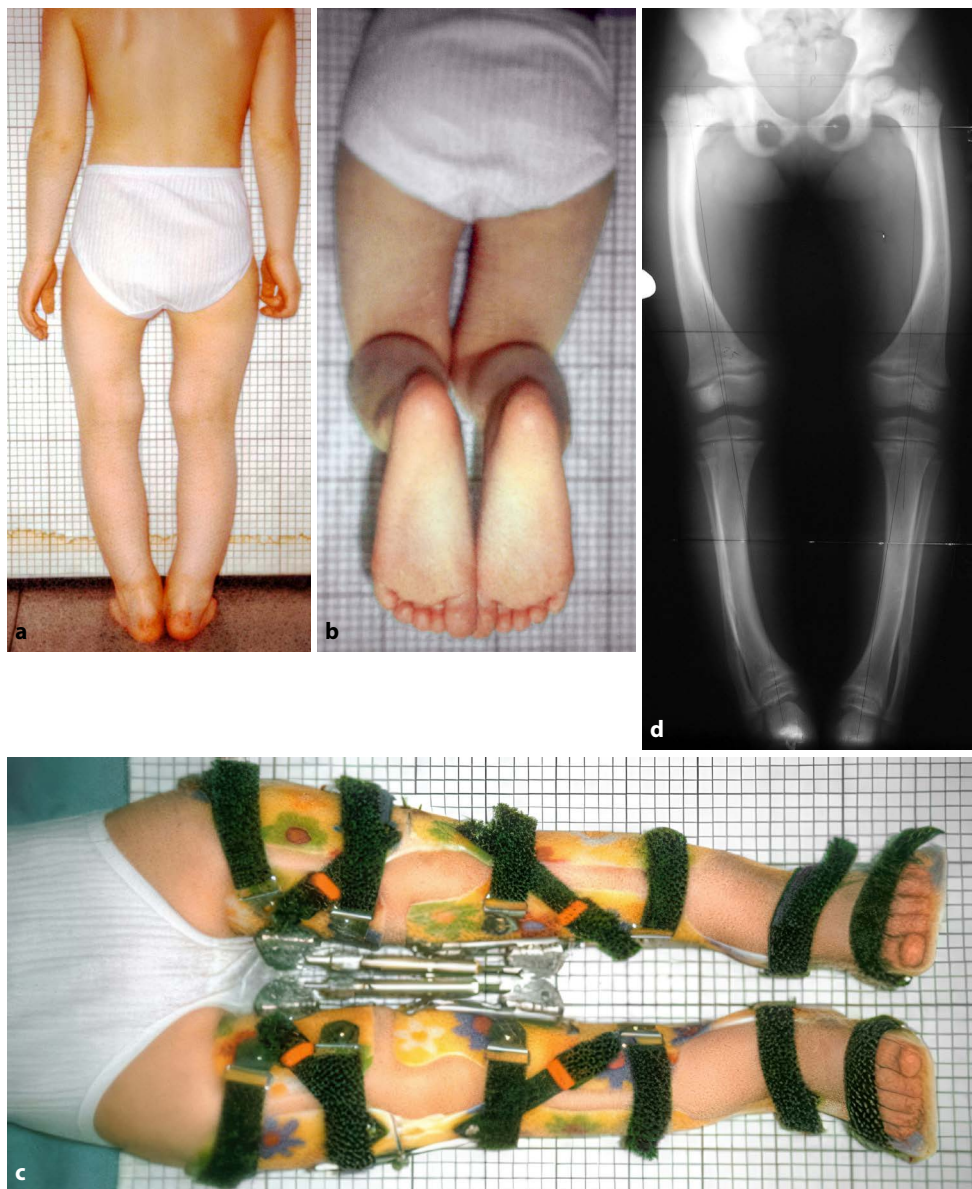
a. lower limbs from behind in standing position in a girl at the age of 5 years, intercondylar distance 2.8 cm, lying down 2.5 cm; b. internal tibial torsion approx. 5°; c. fitting of lower limbs with new orthoses with preload in the frontal plane after fibula resection in the distal 1/3 with shortening (performed at the age of 4 years; note that the correction of varus is at the level of the supracondylar region); d. tele-radiography of the lower limbs in standing at 5.3 years: tibiofemoral angle right/left 5°/6°; varus of both lower limbs is similar to that at 3 years, but rachitic changes are less pronounced. The shortening osteotomy of the distal fibula is completely remodelled bilaterally, but overgrowth is again present.
